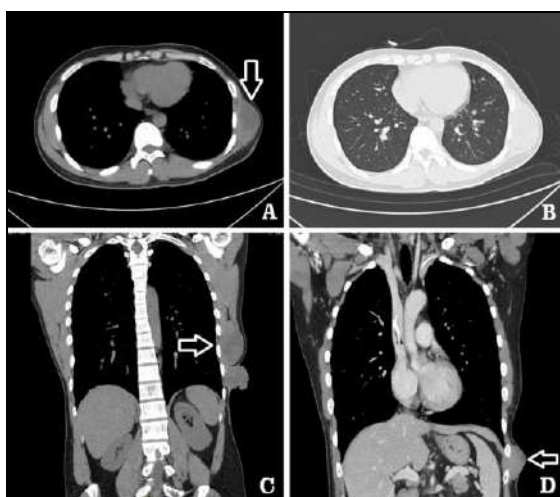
Preoperative CT examination. A, B. Horizontal plane; C, D. Coronal plane
